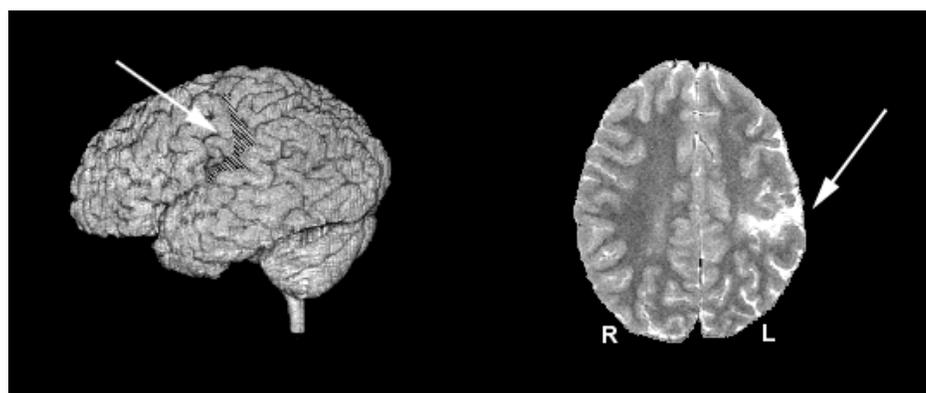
Lateral and axial MRI views of K.–LH showing the location and extent of his brain lesion (adapted with permission from Moses et al., 2000a).
